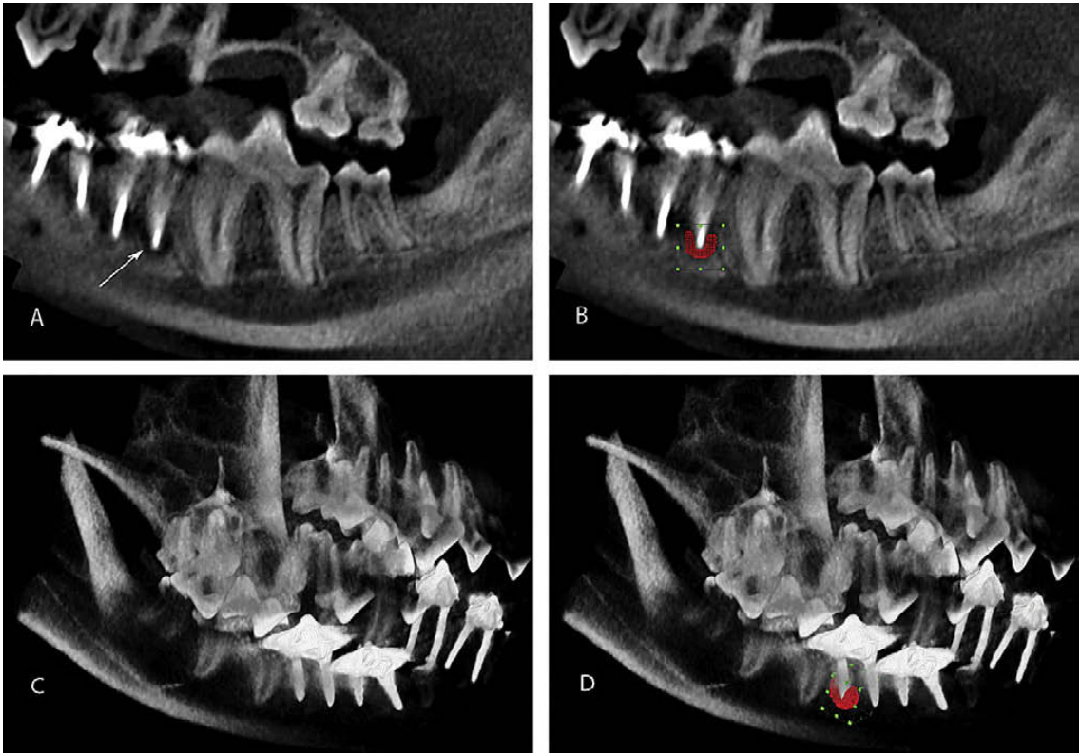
An example of the segmentation procedure on a CBCT scan. The lesion is visible (arrow) on (A) a two-dimensional sagittal slice and is highlighted in red (B). A three-dimensional volume-rendered image of the jaw is shown in C, and the lesion is highlighted in a three-dimensional view in D. The green box shows the region of interest selection.
